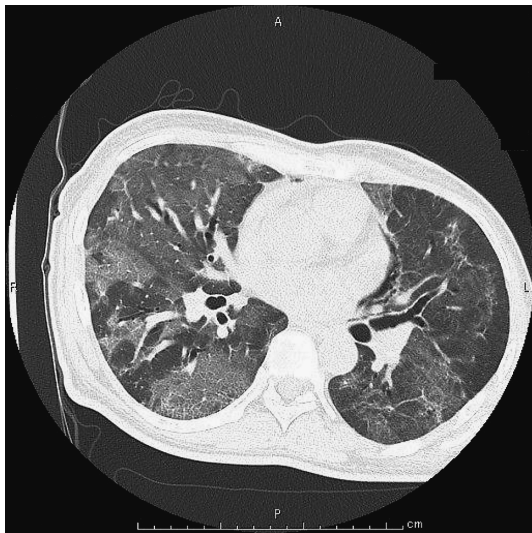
CT revealed marked patchy-to-almost diffuse ground-glass opacity.
